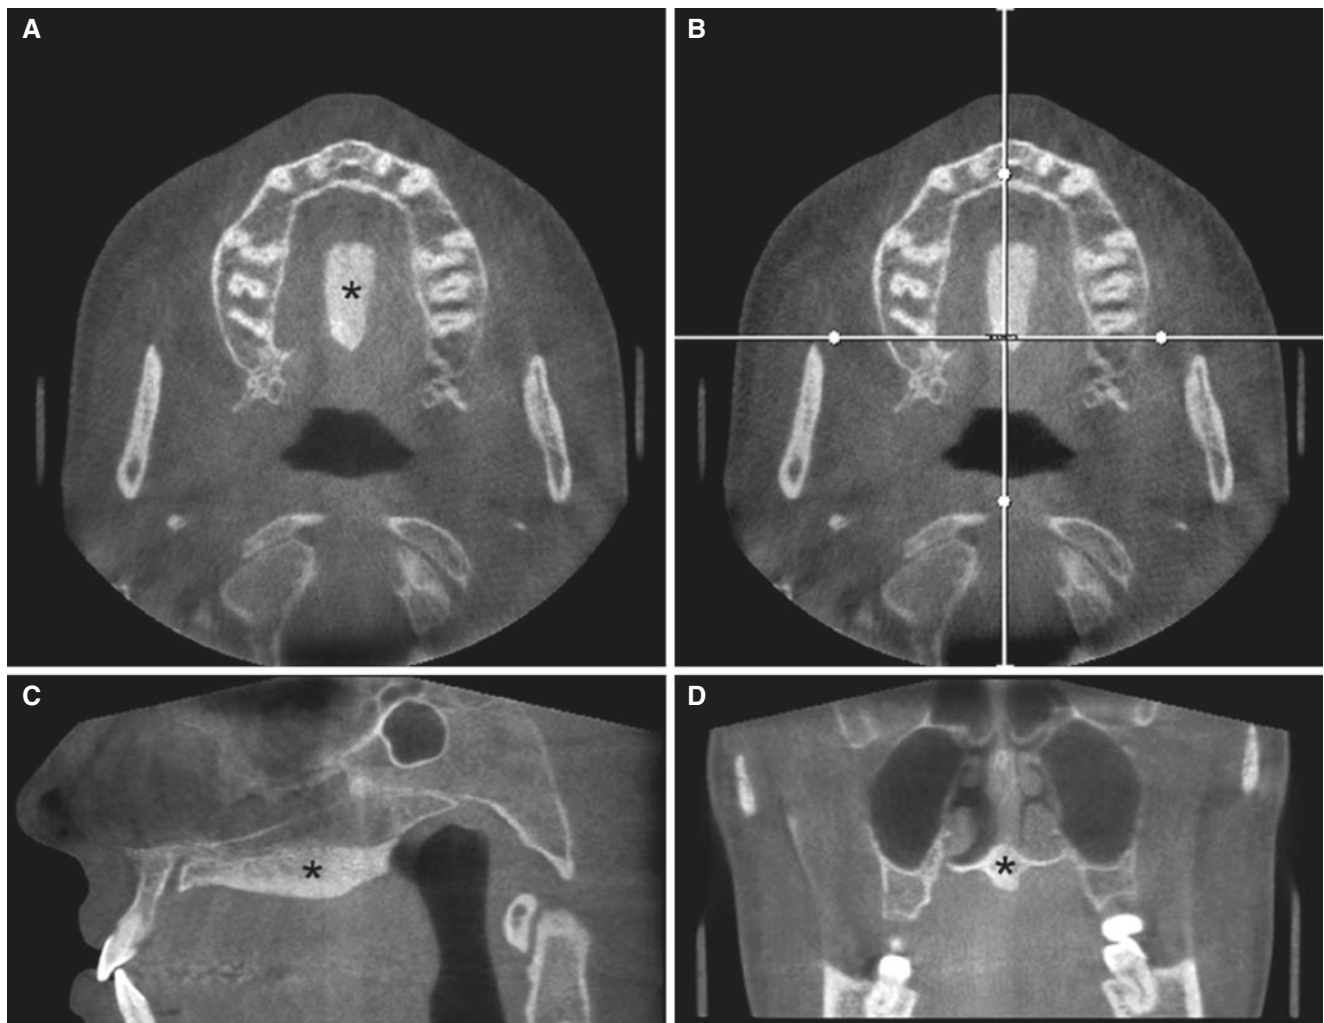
Torus palatinus; 37-year-old female with incidental finding. (A) Axial, (B) axial (with cursor lines), (C) sagittal, and (D) coronal CBCT images show bony outgrowth in the midline of the hard palate (*asterisk*)
